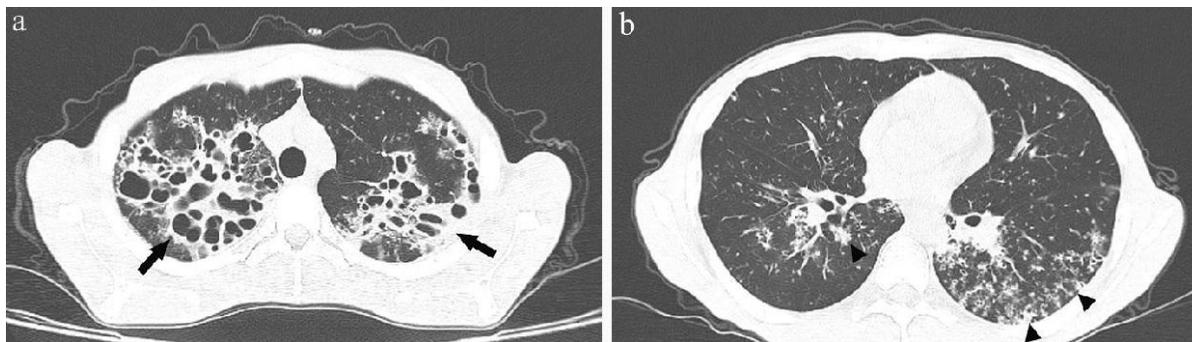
A case of COVID-19 pneumonia confirmed by RT-PCR. 60-year-old man, day 7 after symptom onset, with moderate severity criteria. Axial chest CT shows bilateral subpleural ground glass opacities (arrow) with vacuolar changes (arrowhead). Time to conversion: 12 days.
